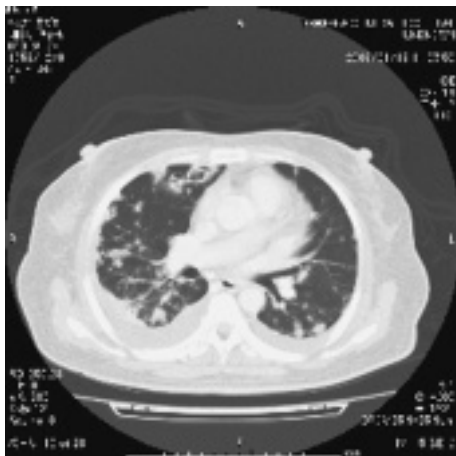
Chest computed tomography shows multiple nodular lesions in bilateral lungs.
